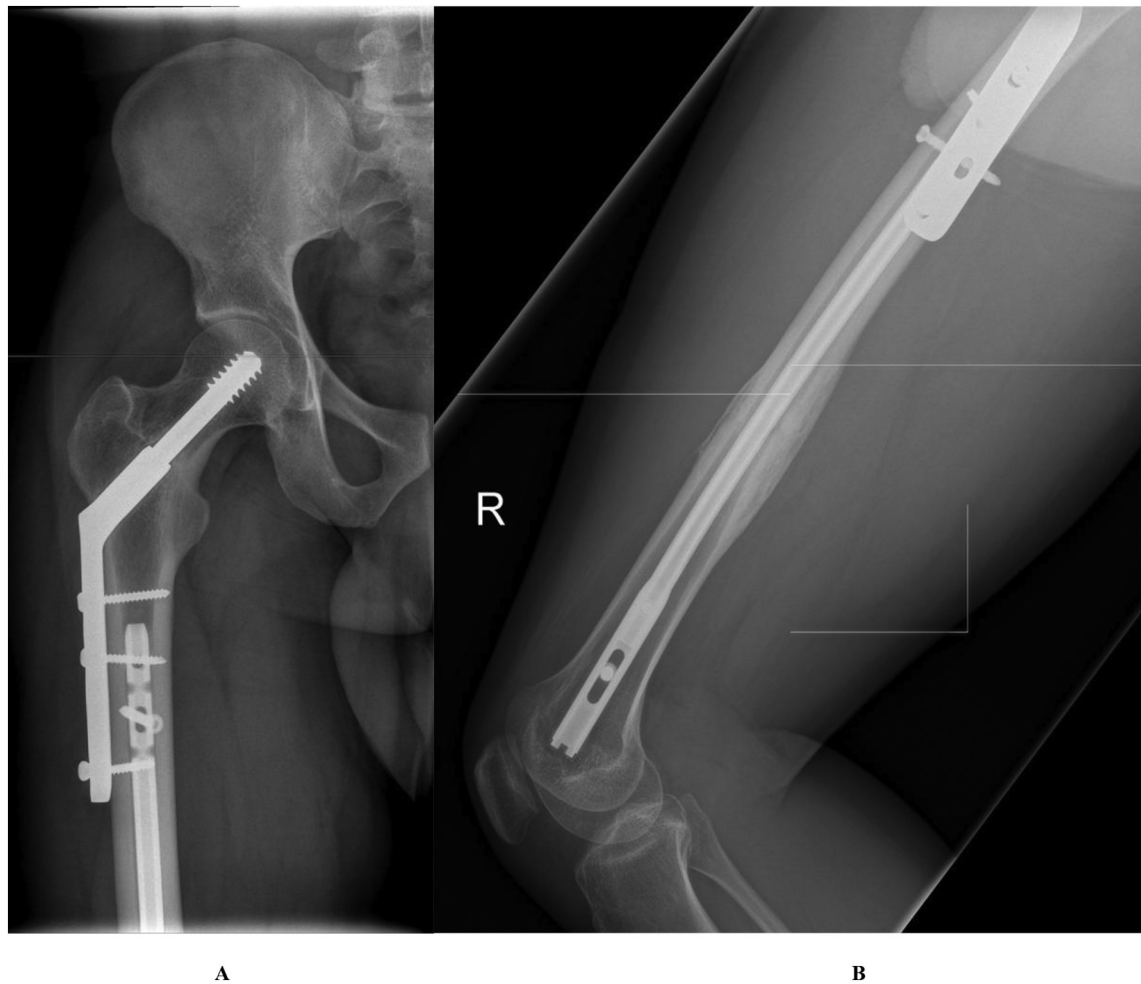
A: Anteroposterior radiograph showing complete healing of the femoral neck fracture.
